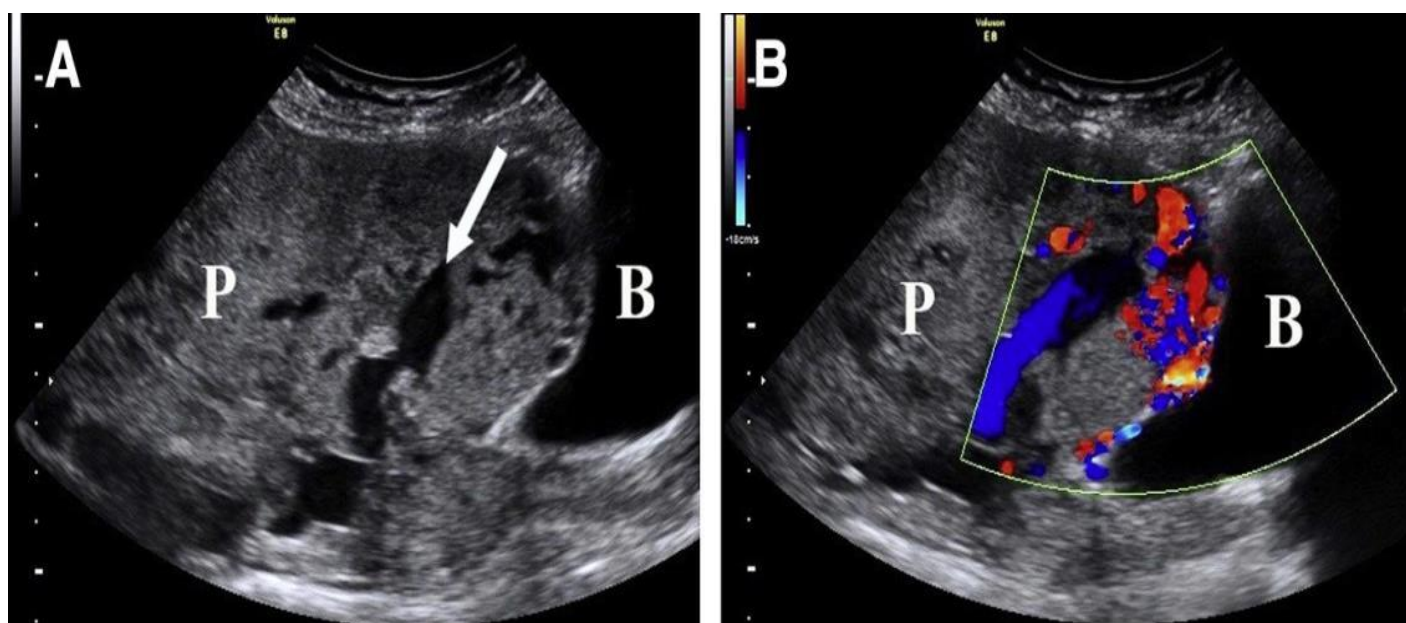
Transabdominal ultrasound longitudinal views of placenta (P) previa accreta at 36 weeks. A, “Moth-eaten” area with numerous lacunae of different size and shape secondary; and B, high-velocity, turbulent blood flow within lacunae on color Doppler imaging next to bladder (B) [24]
